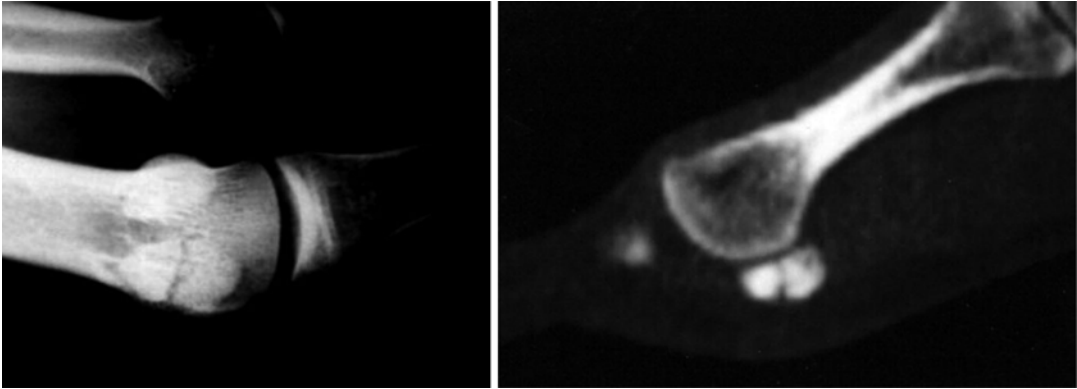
X-ray and CT scan showing a sesamoid stress fracture
